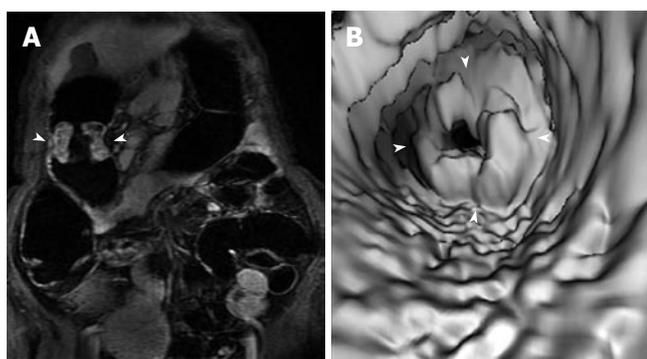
79-year-old woman with history of right upper quadrant pain. A: Coronal gadolinium enhanced T1-weighted image shows an obviously enhanced 6 cm carcinoma (white arrowheads) in the transverse colon; B: Virtual endoscopic rendering confirms the carcinoma (white arrowheads).
